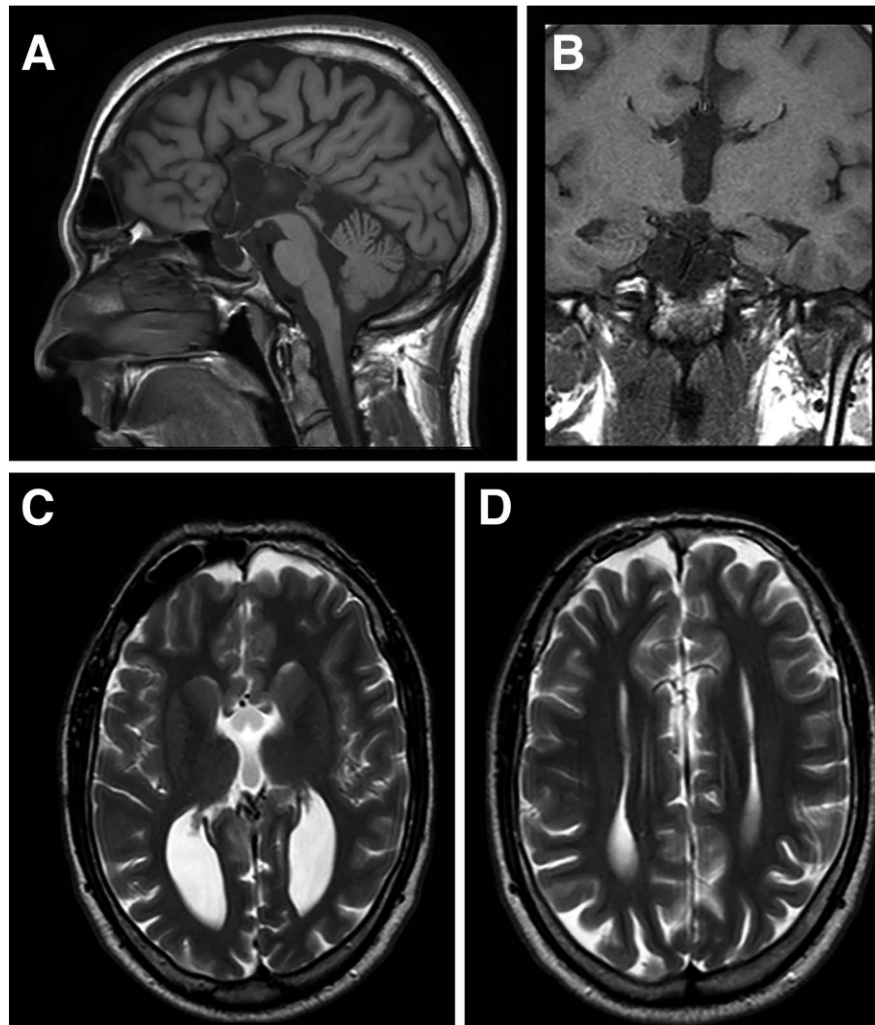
Main MRI findings of the patient G.M. A. T1 sagittal image shows complete agenesis of the CC; the third ventricle was dilated. The herniation of chiasmatic cistern was also evident. B. T1 coronal image showed classical “viking helmet” of the lateral ventricles; third ventricle communicating with the interhemispheric fissure. C and D. T2 axial images showed colpocephaly and parallel lateral ventricles.
